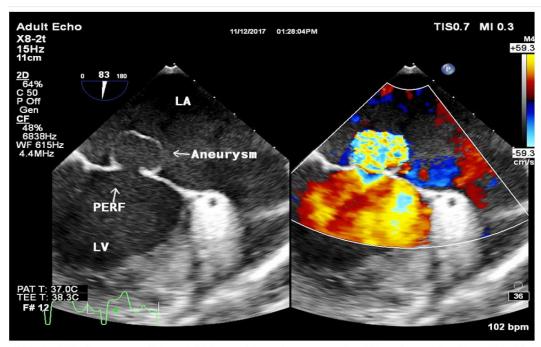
Transoesophageal Echocardiography two chamber view showing globular aneurysm of anterior mitral leaflet with perforation (PERF) at ventricular side. Colour Doppler shows a FIREBALL like appearance. LA: left atrium, LV: left ventricle.
